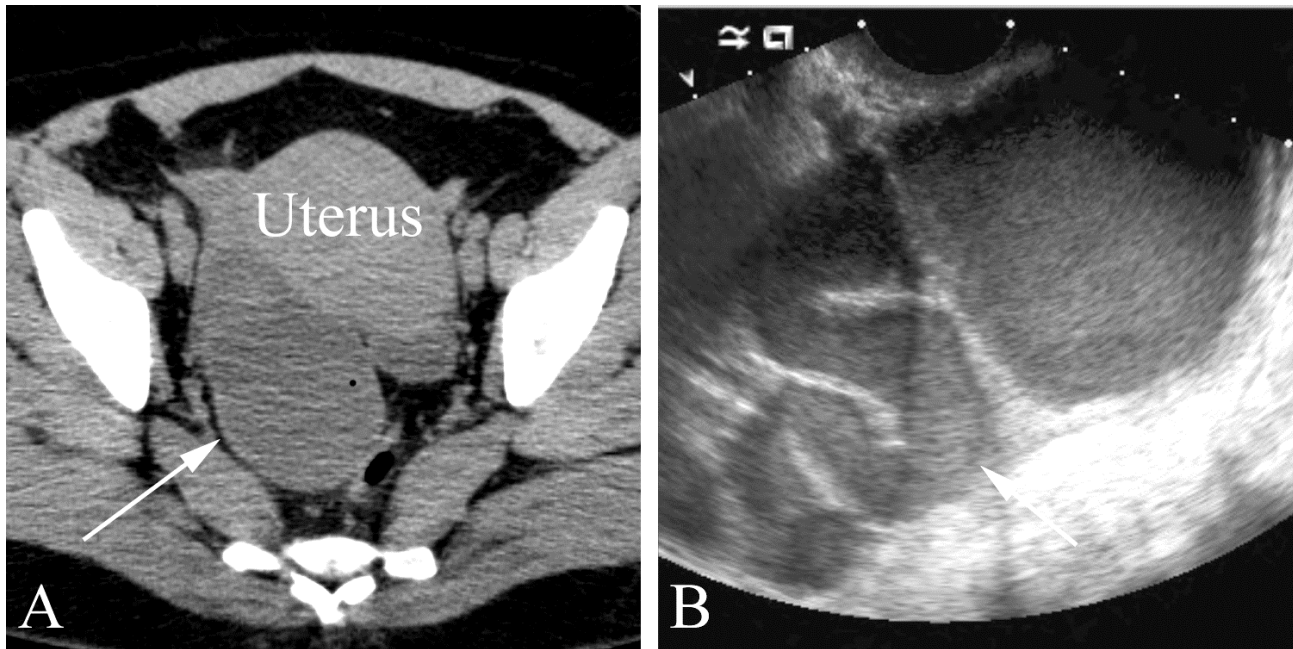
Pyosalpinx in a 42 year old woman with chronic right adnexal and lower abdominal pain. CT supplemented with US to arrive at a diagnosis. A. Axial CT shows an apparent large right adnexal cyst (arrow). B. Pelvic US demonstrates a “tadpole” appearance, characteristic of a hydrosalpinx or pyosalpinx. The patient had surgical resection of the right ovary and fallopian tube demonstrating pyosalpinx superimposed upon a chronic hydrosalpinx.
